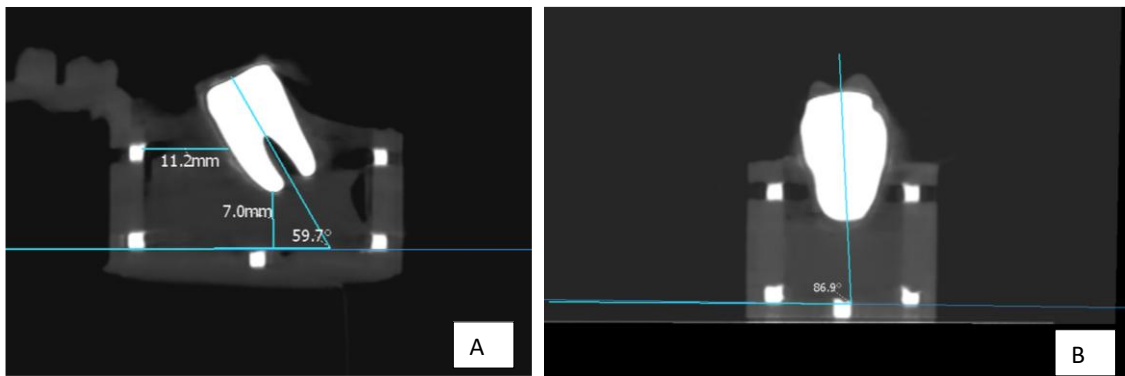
Initial records from CBCT A: Sagittal plane, B: Coronal plane.
